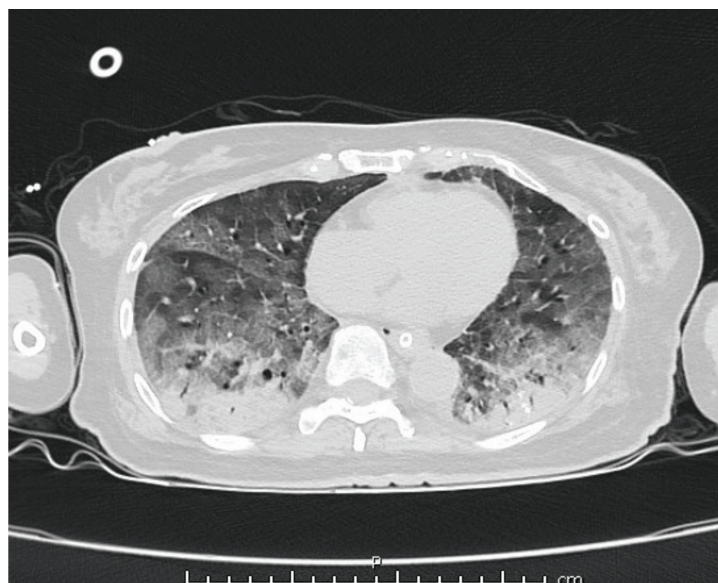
Chest computed tomography shows ground-glass opacities at anterior part of bilateral lungs and consolidations at bilateral posterior lobes of a 71-year-old woman with COVID-19 pneumonia in a respiratory care unit at Thammasat University Hospital, Thailand (day 14 after onset of illness).
